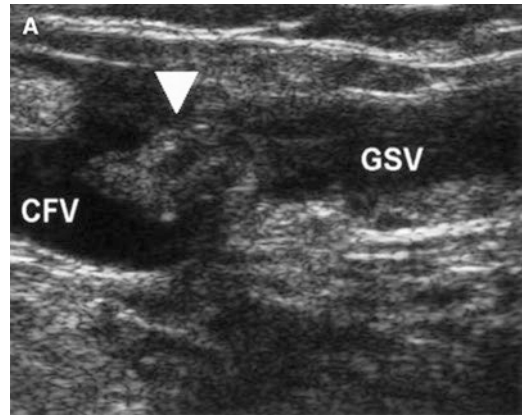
Ultrasound appearance of EHIT, when thrombus has extended into the deep vein from the saphenous vein (GSV = great saphenous vein and CFV = common femoral vein)
